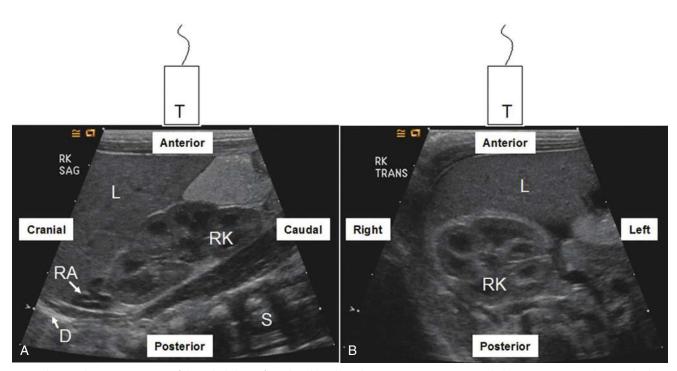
Ultrasound image orientation of the right kidney of a 2-day-old male in the supine position. A, Sagittal plane. B, Transverse plane. D, diaphragm; L, liver; RA, right adrenal; RK, right kidney; S, spine; T, transducer. Note the normal undulating contour of the right kidney secondary to fetal lobulation and the corticomedullary differentiation with hypoechoic renal pyramids. The right adrenal gland is Y-shaped with a bright (echogenic) center and dark (hypoechoic) cortex. The diaphragm appears as a curvilinear echogenic structure.
